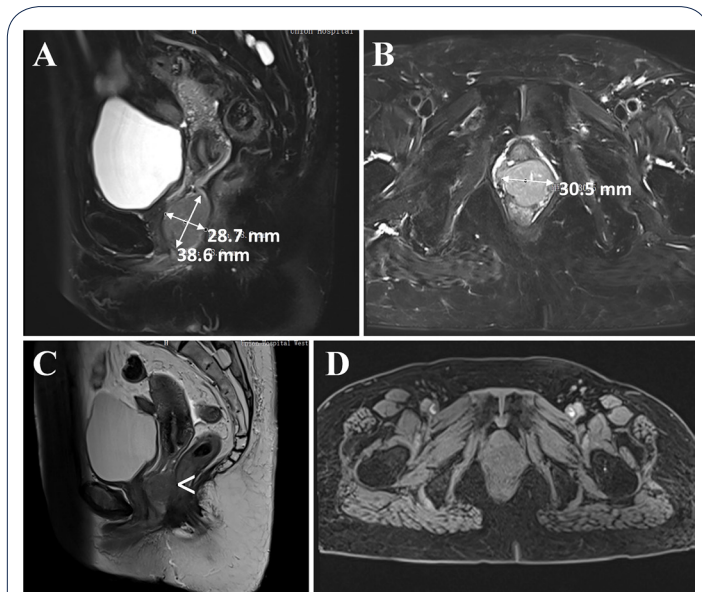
MRI revealed a tissue mass at the back of the vagina, with uneven enhancement and unclear borders with the lower rectum's anterior wall.
